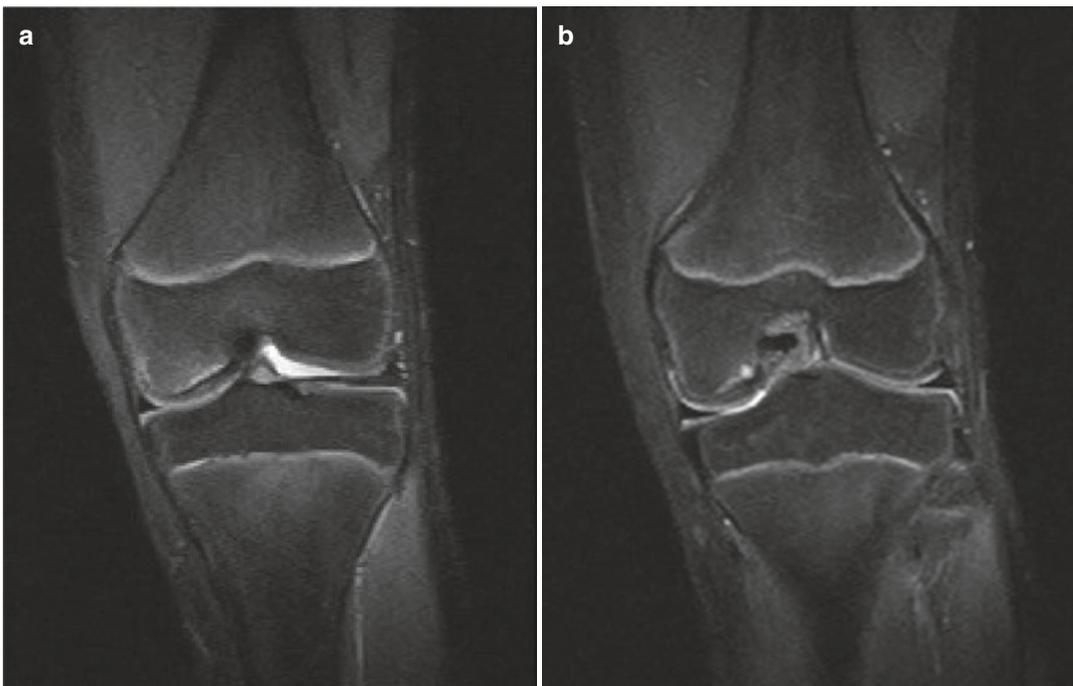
(a and b) Coronal T2 MRI sequences demonstrating an osteochondral lesion about the medial femoral condyle (MRI)
